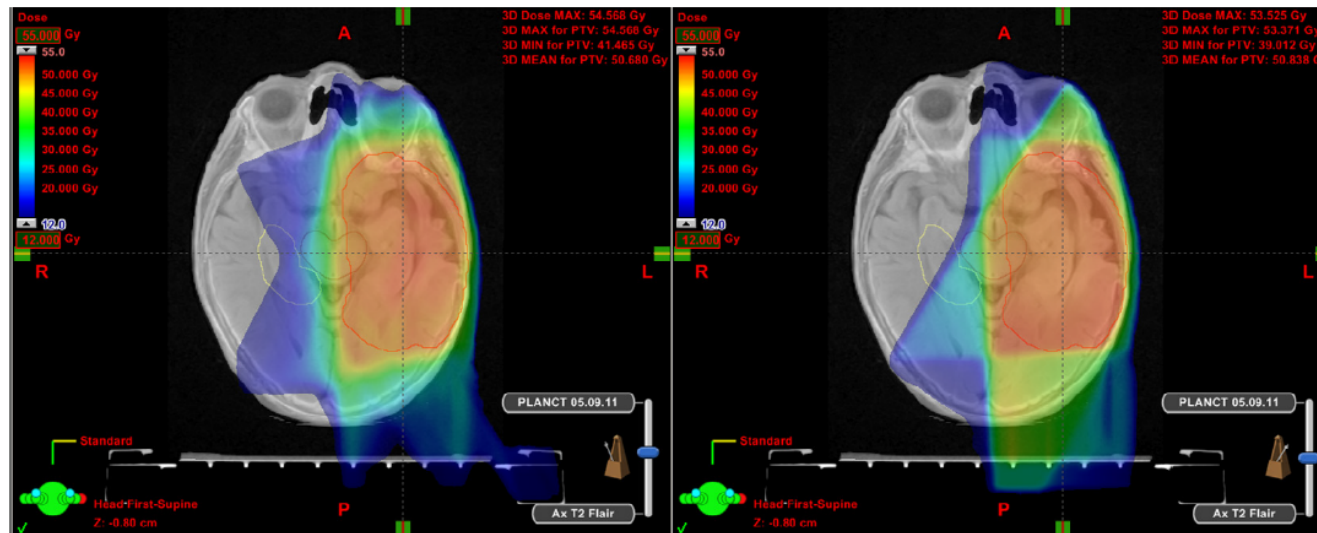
Axial planning CT scans fused with T2-weighted fluid attenuated inversion recovery sequence MRI showing isodose distributions for a representative patient planned with intensity modulated radiotherapy (IMRT) (left) and conventional three-field three-dimensional conformal radiotherapy (right) techniques. The patient has a debulked World Health Organization grade II oligodendroglioma of the left temporal lobe and the dose prescribed to the planning target volume (red line) is 50.4 Gy in 28 fractions. The IMRT plan is more conformal and dose delivered in the intermediate range (25–45 Gy, cyan-green-yellow colourwash) is reduced, including that to the contralateral hippocampal avoidance volume (yellow line).
